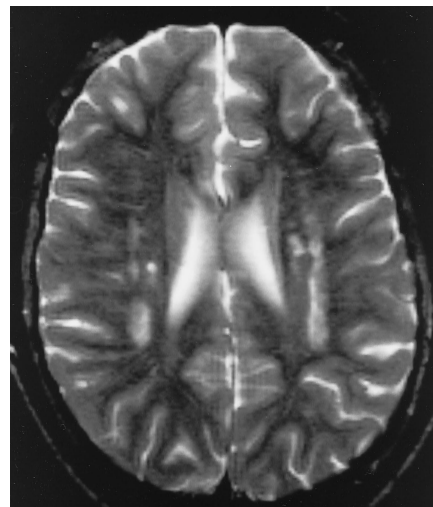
Case 2: 38-year-old man with SLS. Axial turbo spin-echo T2-weighted image (3500/90/2) through the centrum semiovale shows hyperintense lesions in the deep periventricular white matter in both hemispheres. The white matter lesions are confluent in appearance. Note the widening of the peripheral subarachnoid spaces, indicating mild cortical atrophy.
